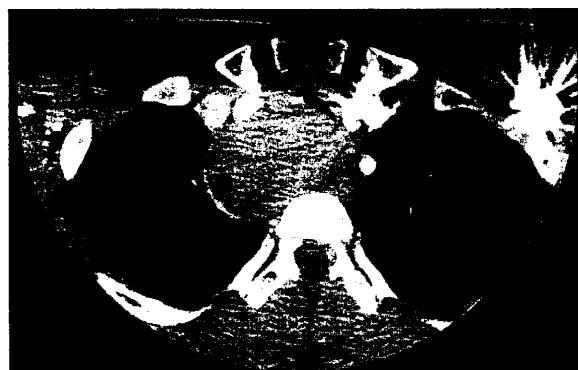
Computed tomographic scan of the thorax in the coronal plane. A large anterior mediastinal mass is demonstrated with maximum axial dimensions of 6.5×4.7 cm and craniocaudal extension of 7.6 cm. The trachea is significantly compressed measuring 5 mm in its mid-portion.
